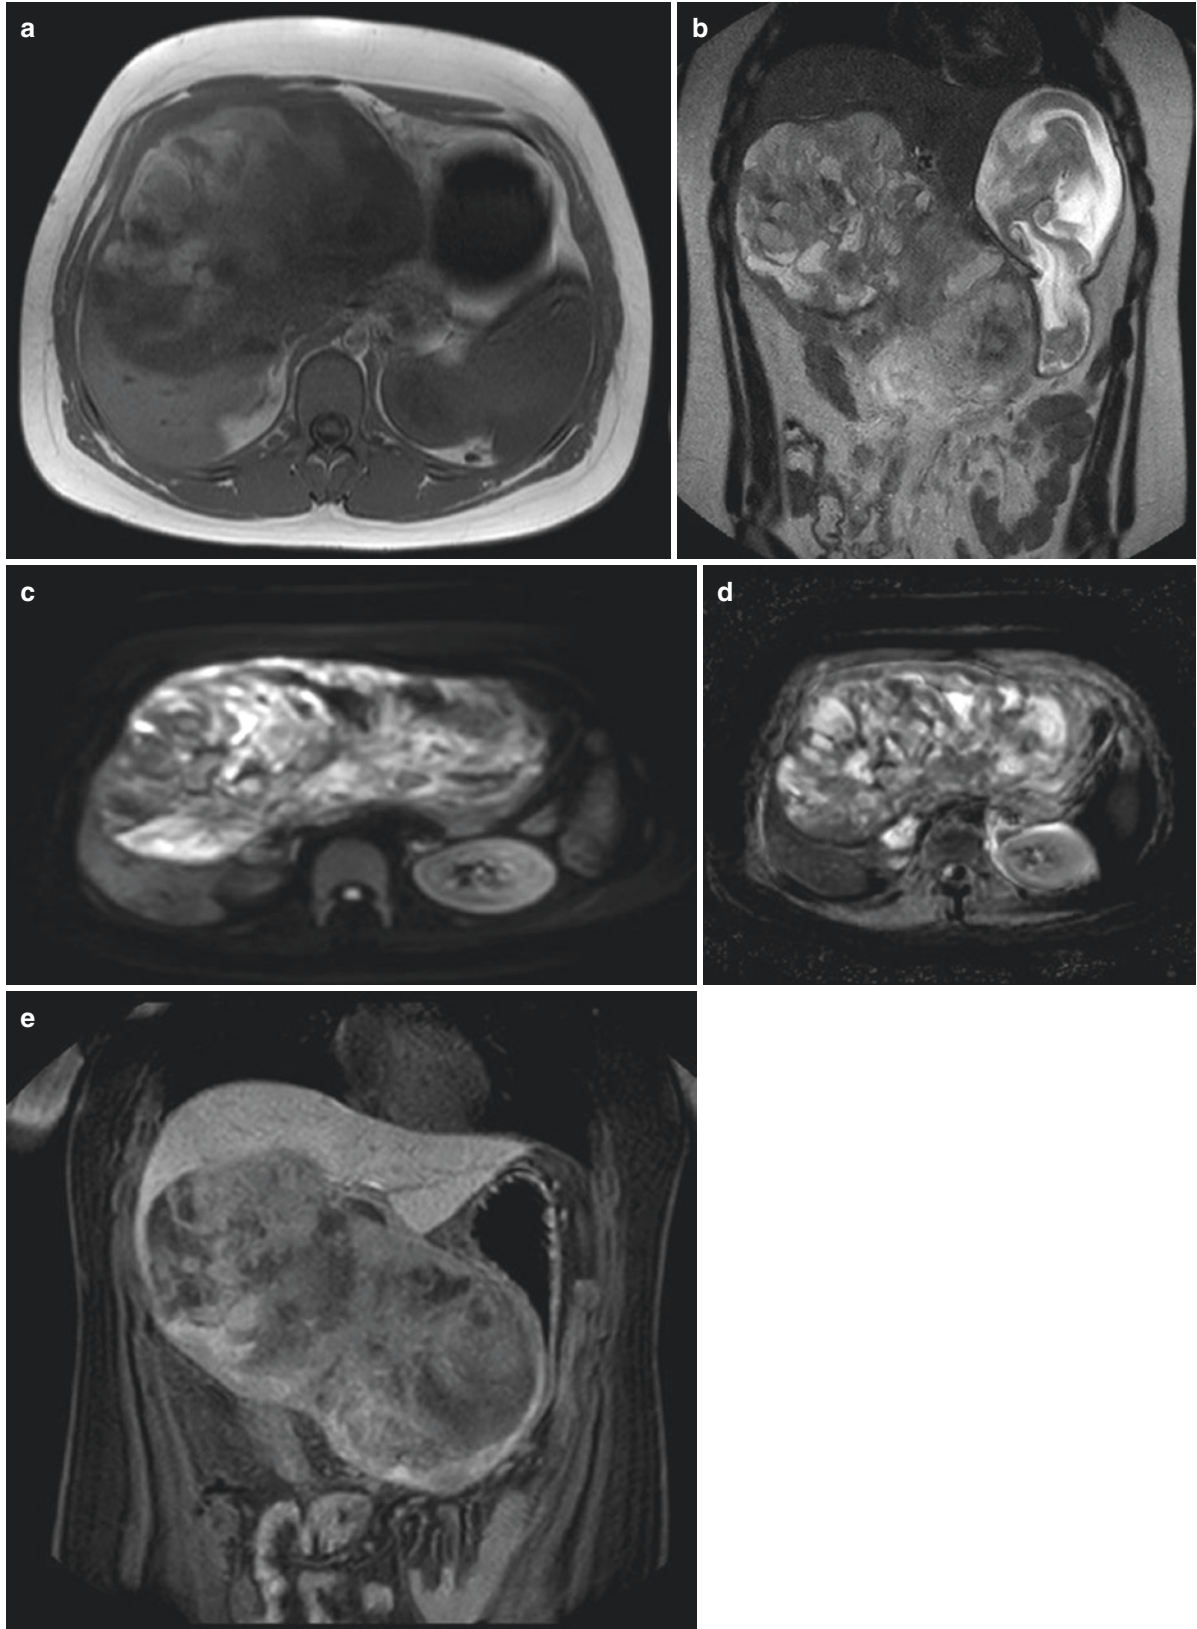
Embryonal sarcoma Large lobulated lesion involving the entire right lobe of liver, heterointensity on T1WI (a) and T2WI (b), restricted diffusion on DWI (c) and ADC (d) with variable contrast enhancement on intravenous gadolinium enhanced fat sat T1WI (e)
